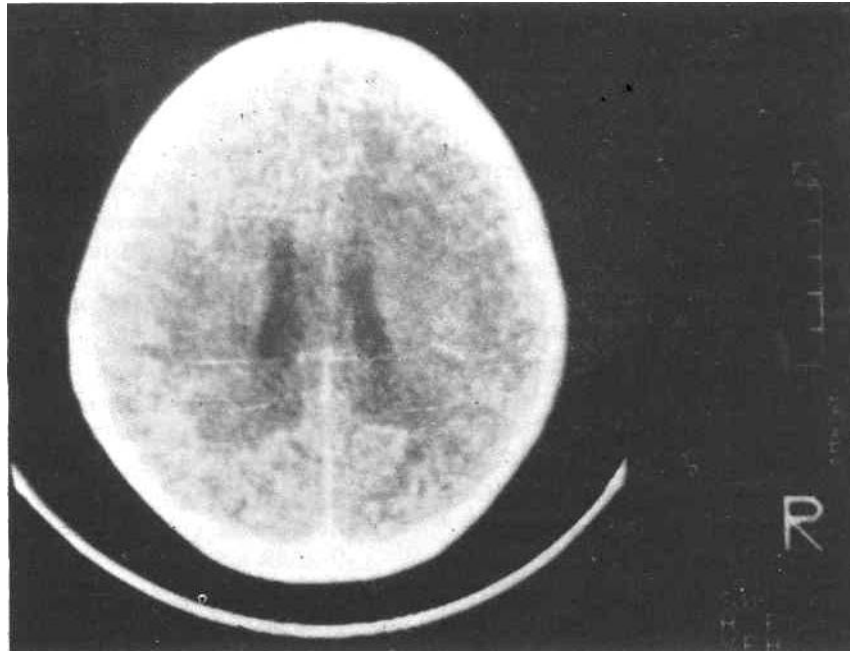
CT scan brain-contrast study shows hypodense areas in parieto-occipital region in white matter close to the gyrus, consistent with leukodystrophy. The sulci and gyri appear normal.
